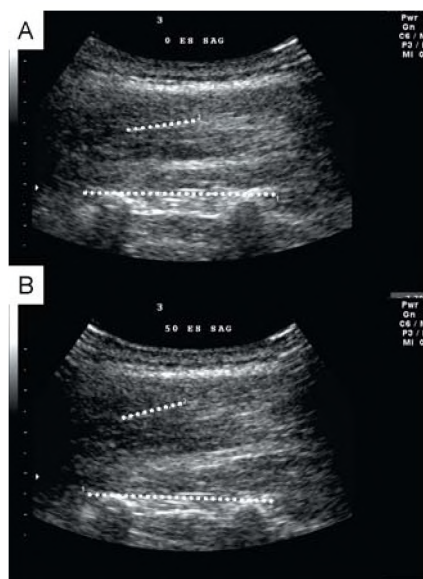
B-mode ultrasound image of longissimus thoracis relaxed (A) and during exertion of 50% of maximal trunk extension force (B).
